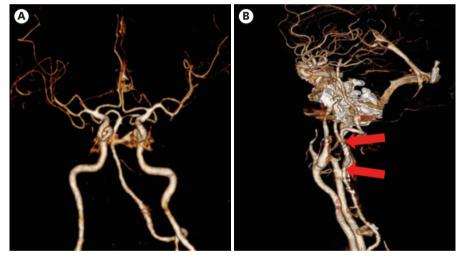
Seven-day postoperative computed tomography angiography. (A) Anterior posterior view. Demonstrating good flow of the posterior circulation, including the vertebro-basilar artery. (B) Lateral view. Red arrows are proximal and distal part of stent.
